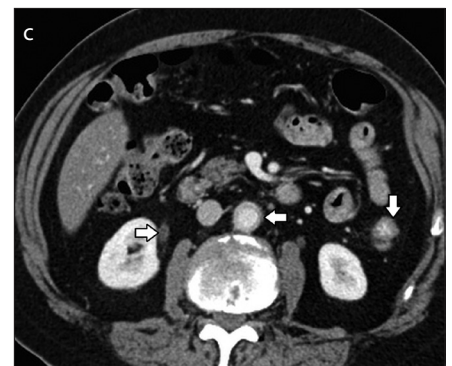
a–c. Axial (a) and coronal (b) CT images show thickening of the abdominal aortic wall with surrounding inflammatory changes in keeping with aortitis (*left arrow*). The image also shows thickening of the colonic wall with pericolic inflammatory fat stranding (*down arrow*). Also note thickening of the right proximal ureter walls (*right arrow*). Axial CT (c) through similar level after 3 months of corticosteroid therapy. Note decrease in aortic wall thickening, right ureter thickening, and resolution of bowel wall thickening and inflammation.
